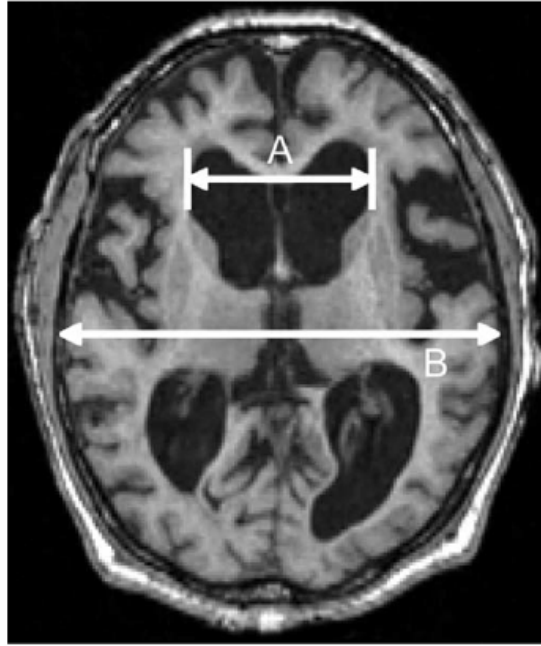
Axial view of T1WI of MRI brain showing hydrocephalus. A= largest width of frontal horns; B= maximal biparietal diameter (Ishii *et al.*, 2008).
